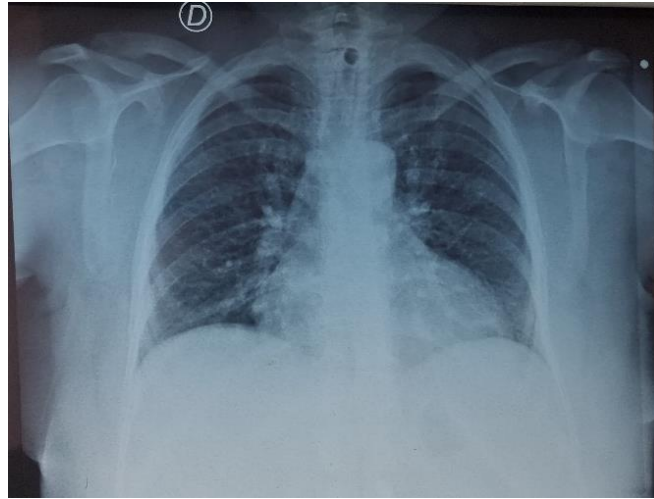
Chest x-ray showing multiple nodular peri-hilar opacities. No suspicious-looking parenchymal lesions on chest scanner
